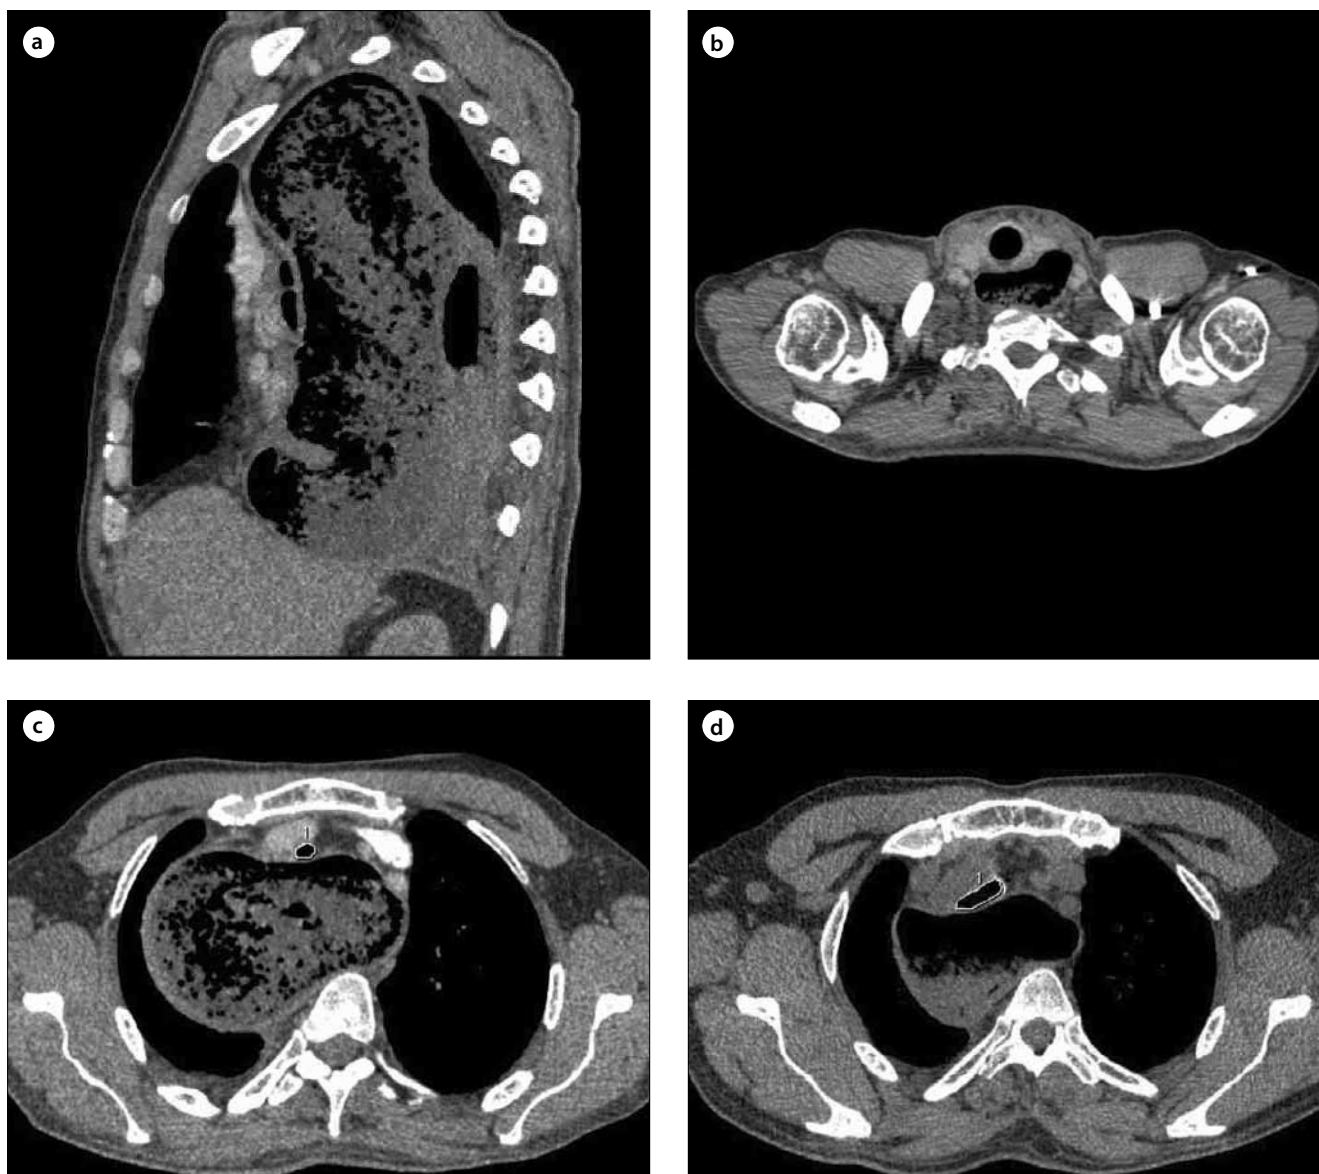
a-d. Sagittally reformatted (a) and axial (b) CT images just below the level of the cricopharyngeus muscle shows dilation of the upper esophagus without evidence of tracheal compression. Axial CT images at the level of the thoracic inlet obtained before operation (c) and after operation (d) demonstrate that the tracheal area is 0.59 mm^2 before and is 1.81 mm^2 after operation. These two examinations were taken approximately at the same level and during deep inspiration. Note that the tracheal lumen becomes approximately 67% greater compared to before the surgery.
